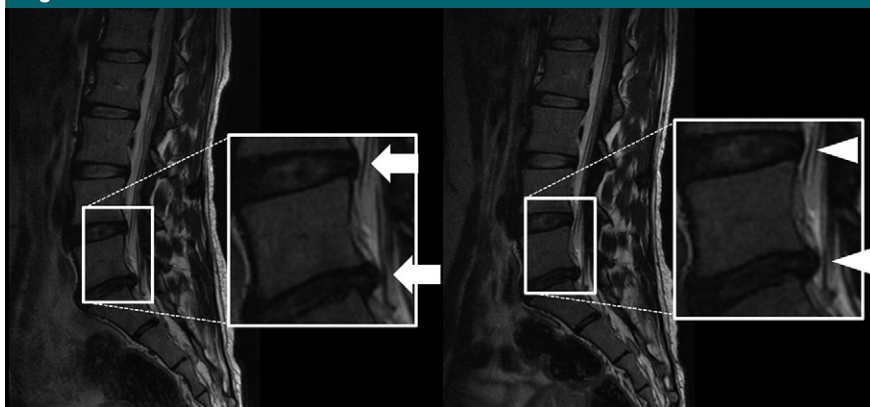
Sagittal MR images of adjoining disk and nerve root before traction (left) and 30 minutes after traction (right). Adjoining disks and nerve roots before the traction (arrows) were separated after 30 minutes of traction. A cerebrospinal fluid cleft was clearly visualized (arrowheads).
